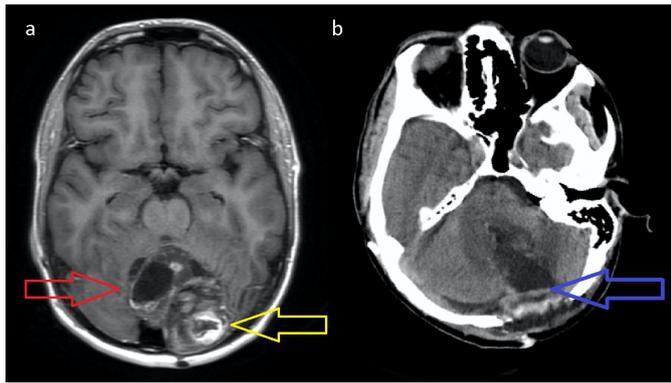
Cystic (red arrow) and solid (yellow arrow) components of the tumoral tissue are seen in the preoperative MRI examination of the patient who was diagnosed with pilocytic astrocytoma (a). Postoperative CT examination reveals superficial hemorrhage under suboccipital craniectomy and tumor resection extending from the midline to the brainstem (b).
